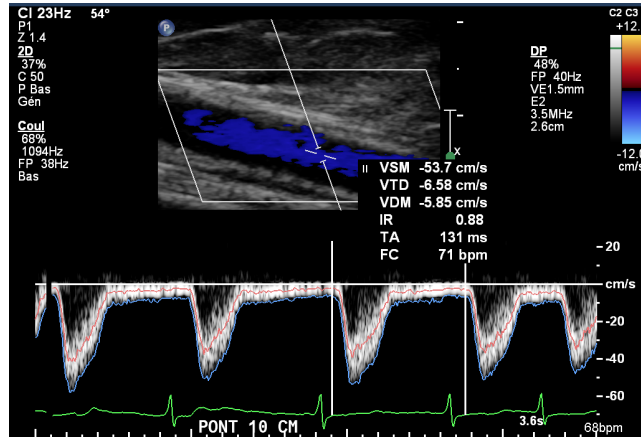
B-mode Doppler ultrasound in a bypass vessel with measurement of the centerline velocity in the central region of the artery delimited by the two cursors.
